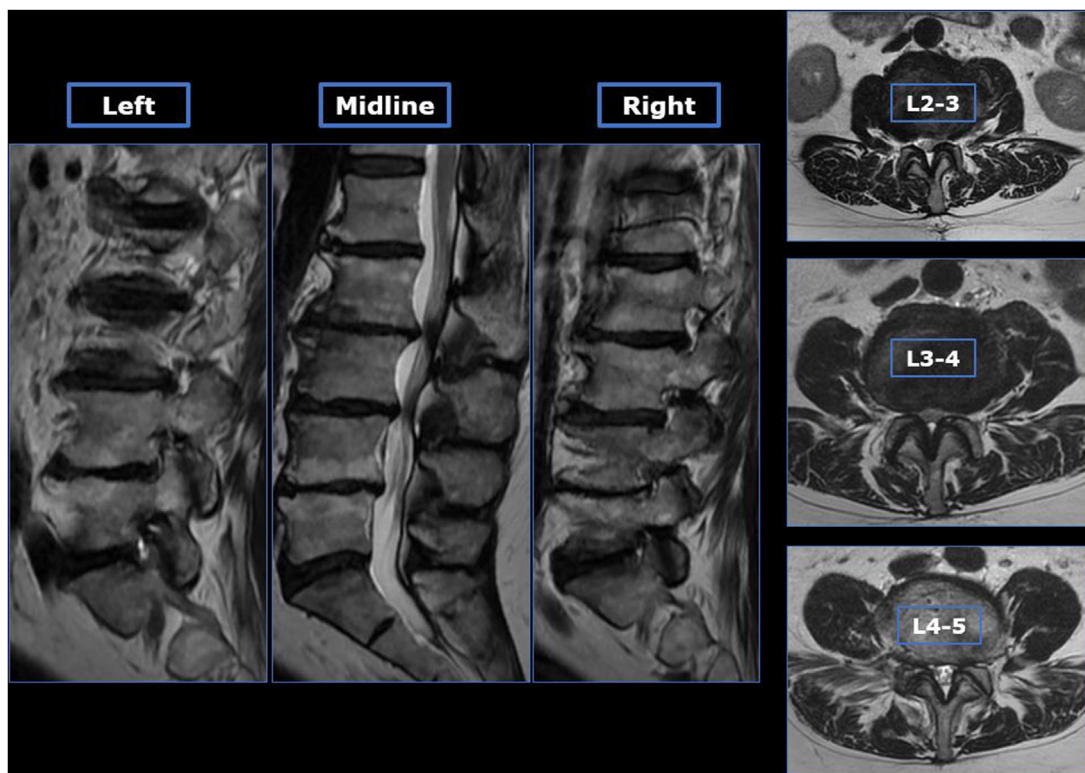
Preoperative MRI.
